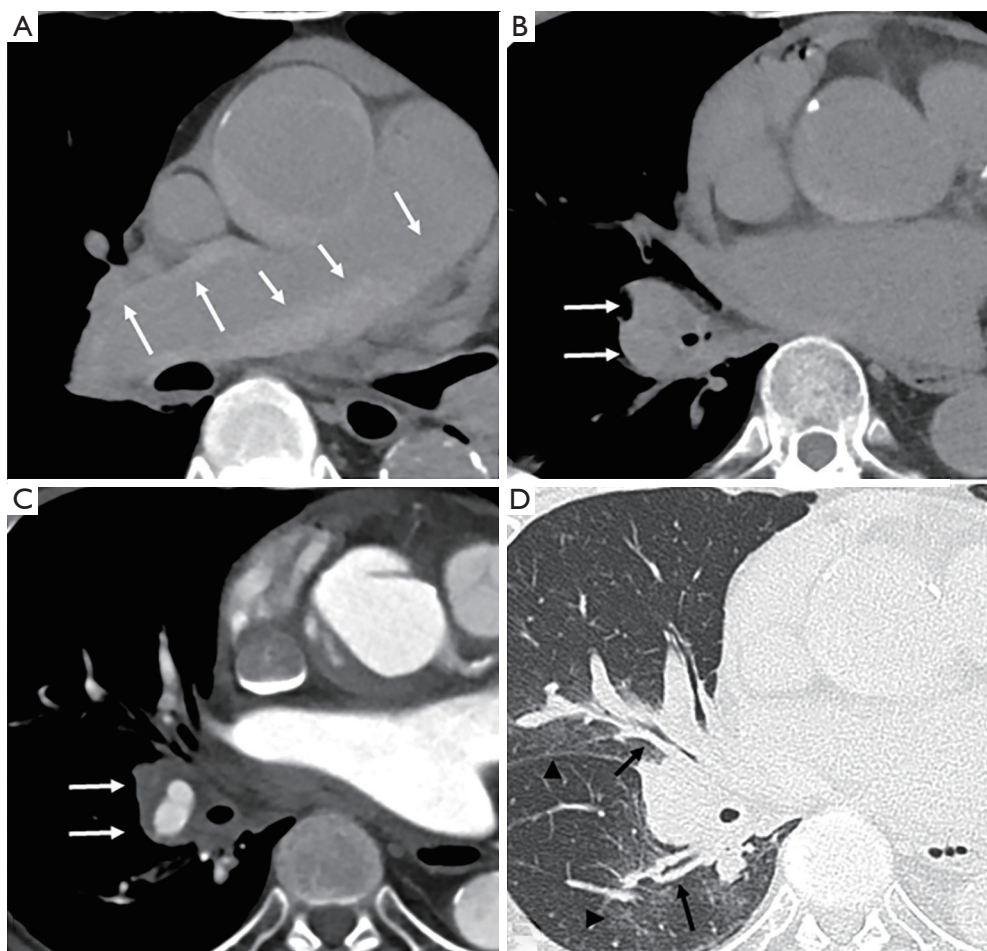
Images for a 91-year-old man with Grade 2 PAPH. (A) Non-enhanced CT showing a relatively thick higher attenuation area than that of blood along the wall of the pulmonary trunk and right main PA (white arrows); (B) non-enhanced CT showing a higher attenuation area than that of blood around the right PA in the right lung field (white arrows); (C) CECT showing no contrast enhancement within the area (white arrows), which was considered a hematoma due to PAPH; (D) CT (lung window setting) showing peribronchovascular interstitial thickening (black arrows) with faint ground-glass opacities (black arrowheads) in the right lung field, indicating peribronchovascular interstitial hemorrhage. PAPH, pulmonary artery periaortic hematoma; CT, computed tomography; PA, pulmonary artery; CECT, contrast-enhanced CT.
